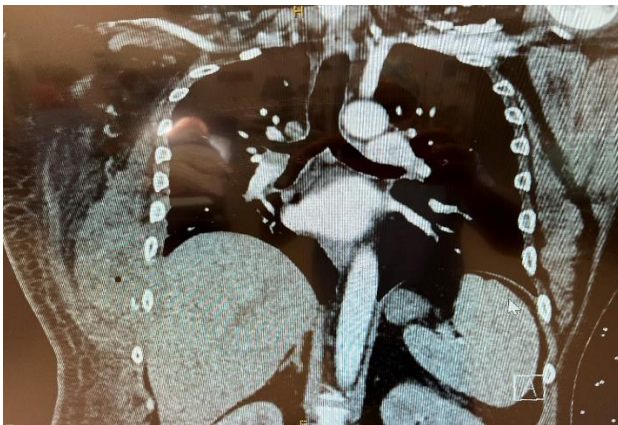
CT scan of the chest and abdomen was suggestive of off ended lower rib fractures with gas locules in a hematoma measuring 13x5 cm.
